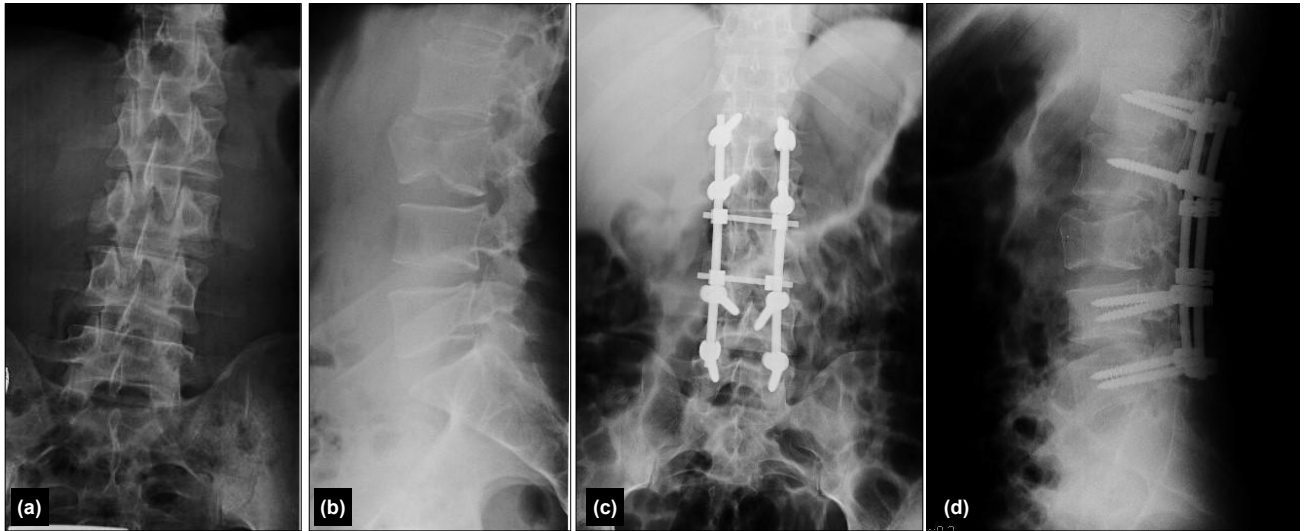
Preoperative (a,b) and postoperative (c,d) plain radiographs of a patient who underwent long segment posterior instrumentation for L3 vertebral fracture.
